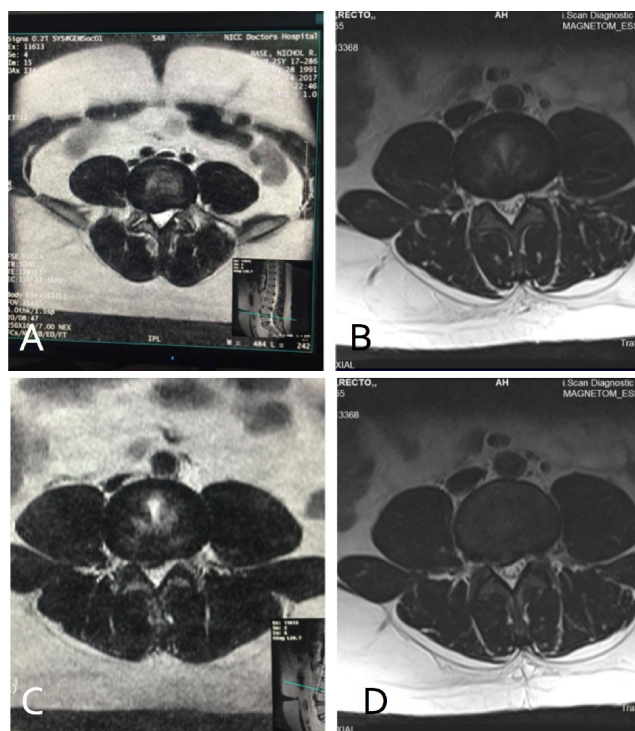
A. Preop MRI L3/L4 disc level B. Postop MRI MRI L3/L4 disc level C. Preop MRI L5/S1 disc level D. Post op MRI L5/S1 disc level
